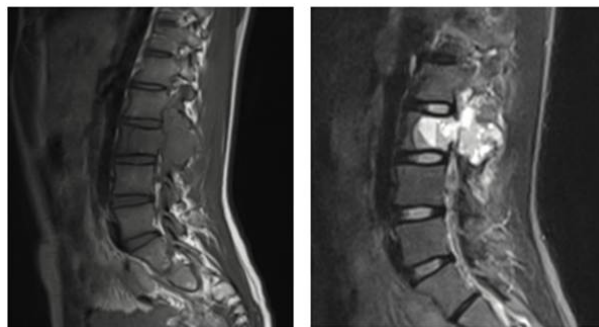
MRI spine showing fluid-fluid levels noted epicentered in left half of L2 vertebral body
